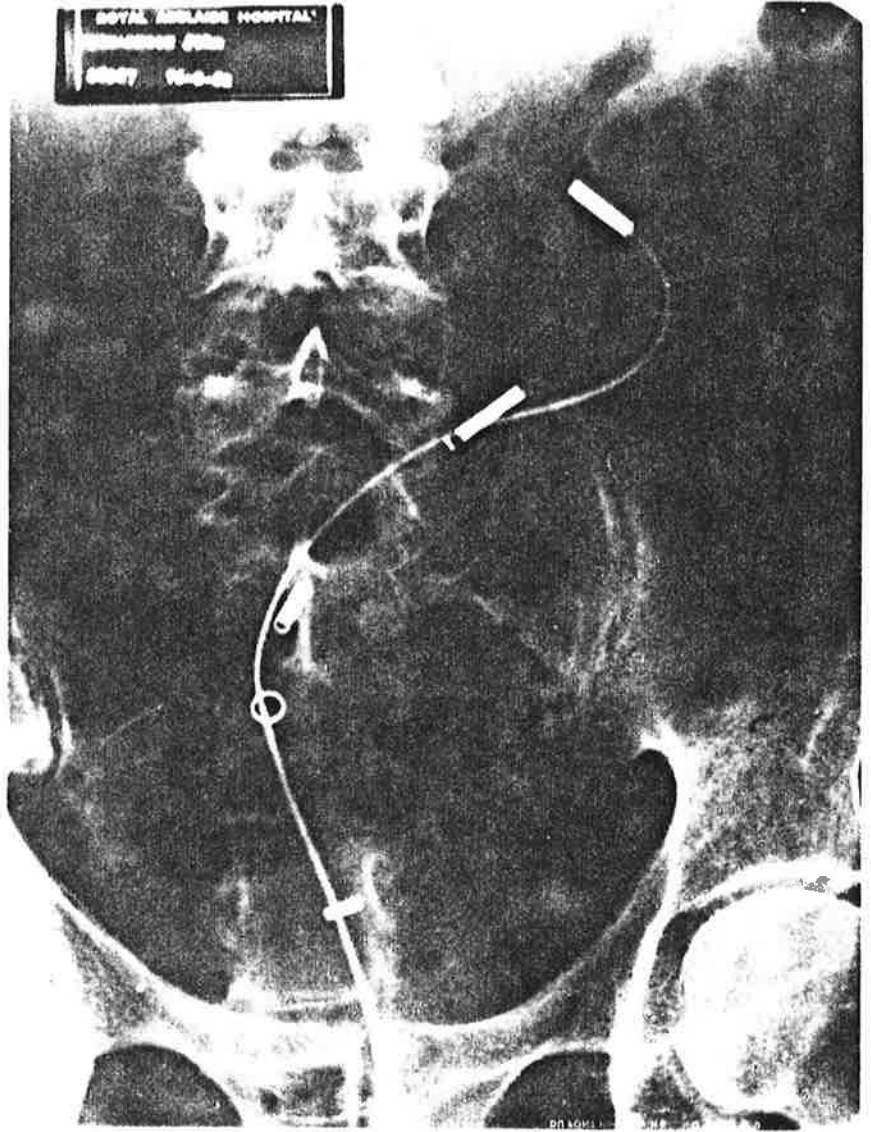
Radiograph showing the position of the catheters in the large intestine. The highest catheter is outlined by radio-opaque contrast medium.
